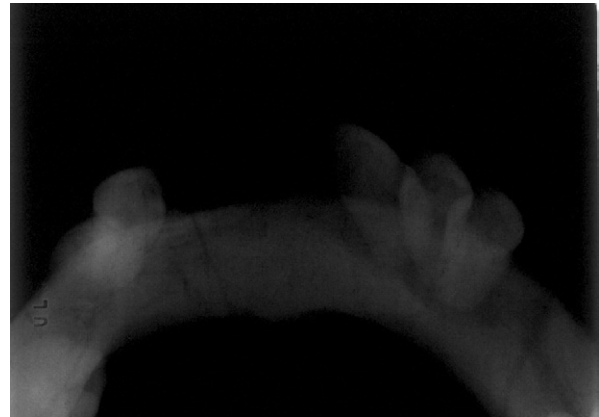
Occlusal radiography of the lesion 14 months after treatment.
